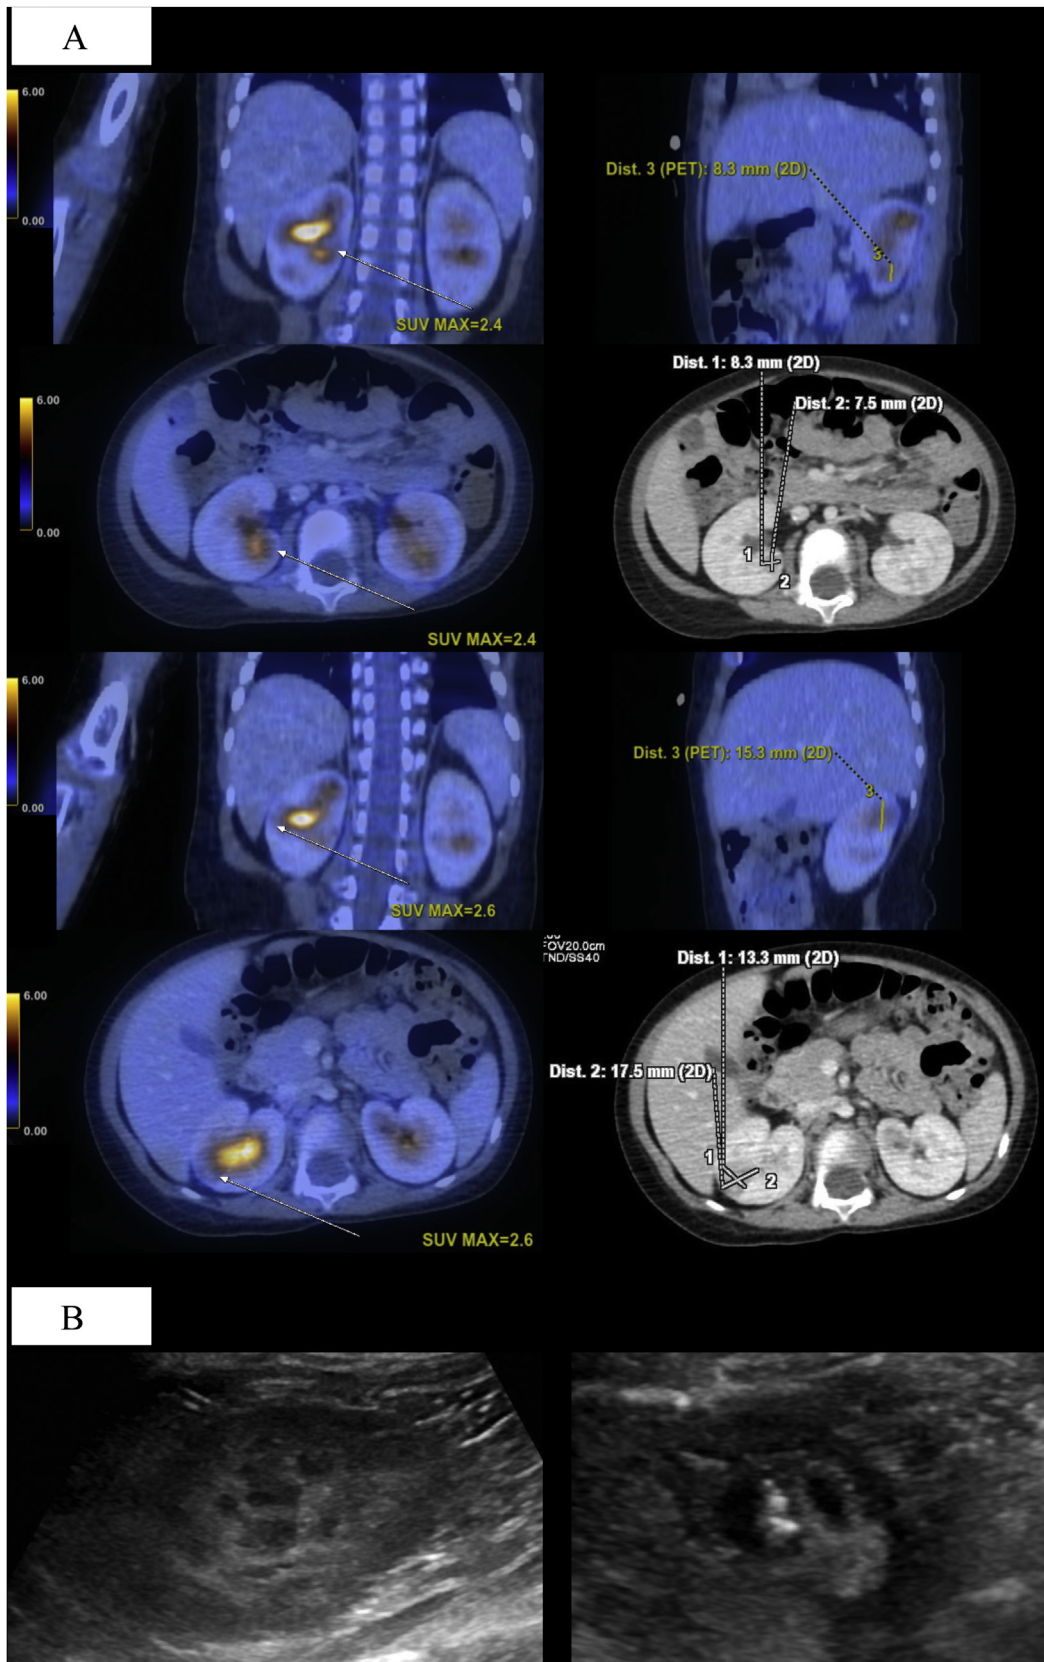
(A) Coronal, sagittal, and transverse views from PET-CT of the abdomen were performed which revealed more hypermetabolic, heterogenous, low attenuation in the renal parenchyma of the right kidney than left kidney. (B) Conventional microbiological cultures from ultrasound-guided aspiration of fluid within multicystic (right upper pole) and smaller hypoechoic (left middle pole) microabscesses were negative, but *Candida tropicalis* was identified using the PCR method.
